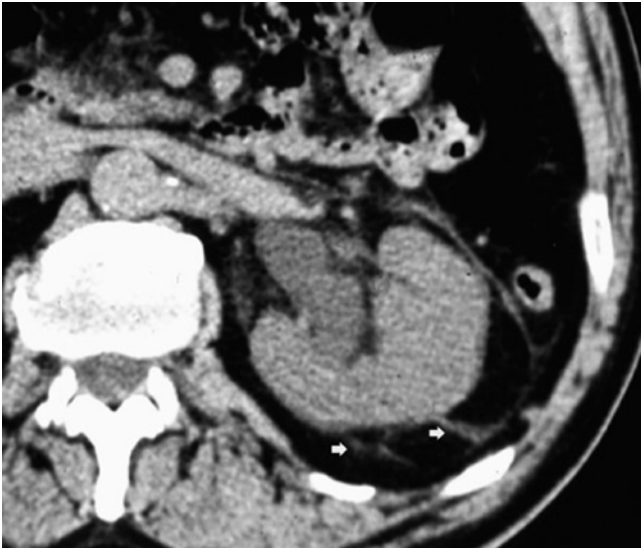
Indirect signs of renal calculi. Unenhanced CT. Transverse plane. Perinephric strandings (*arrows*) surrounding the enlarged left kidney with dilatation of the intrarenal urinary tract (Courtesy of Prof. E. Quaia)
